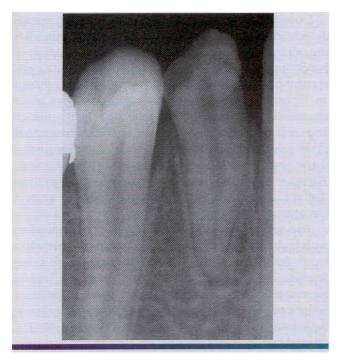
• Turner's hypoplasia. Radiograph of the same tooth depicted in Figure 2-4. Note the lack of significant enamel and irregularity of the dentin surface. (From Halstead CL, Blozi's GG. Drinnan AJ, et al: *Physical evaluation of the dental patient*, St Iouis, 1982, Mosby)
